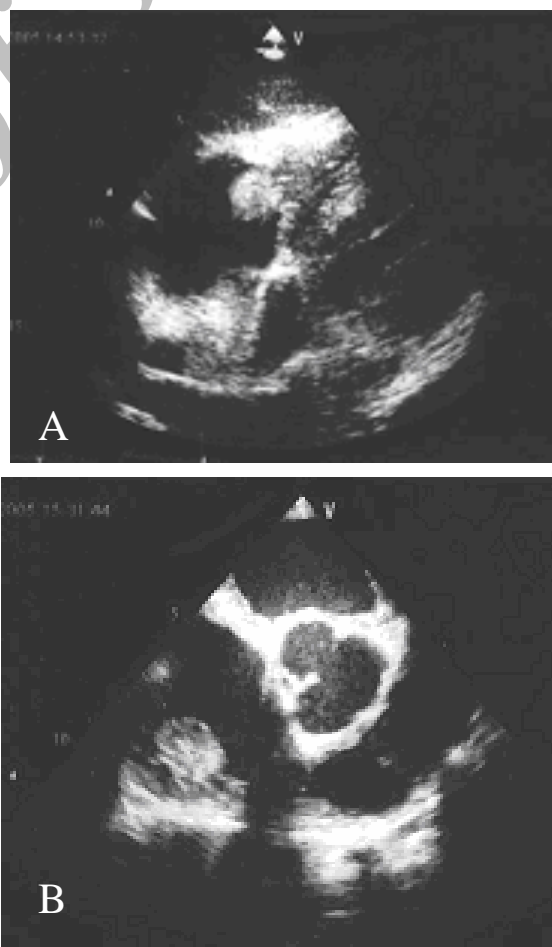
A, transthoracic subcostal view and B, transesophageal RV inflow-outflow view
